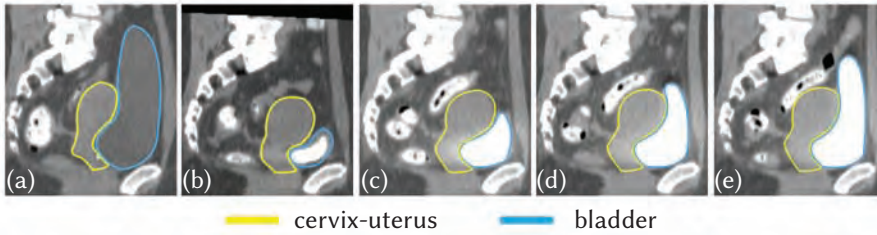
Delineated variable bladder filling CT scans for a cervical cancer patient (sagittal view). The delineated structures are cervix-uterus and bladder. a) Planning CT scan with a full bladder, b) empty bladder, and c-e) repeat CT scans demonstrating the natural filling of the bladder. The bladder in b-e) has a higher intensity than the planning bladder a) due to the washout of the IV contrast.
